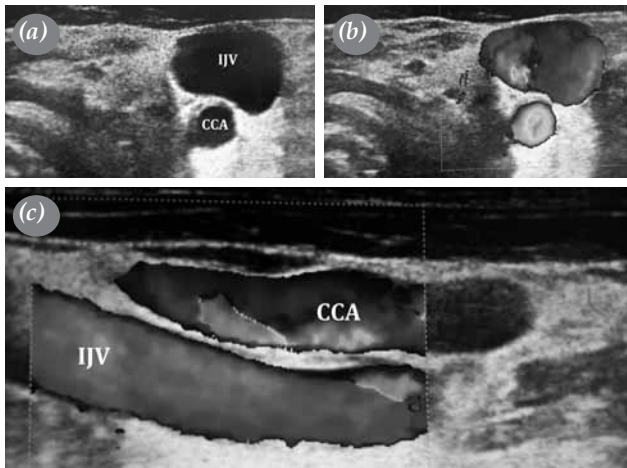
(a) Ultrasound image is showing internal jugular vein phlebectasia. (b) Color Doppler ultrasound is showing internal jugular vein phlebectasia. (c) Color Doppler ultrasound is showing common carotid artery and internal jugular vein alignments in longitudinal axis.
